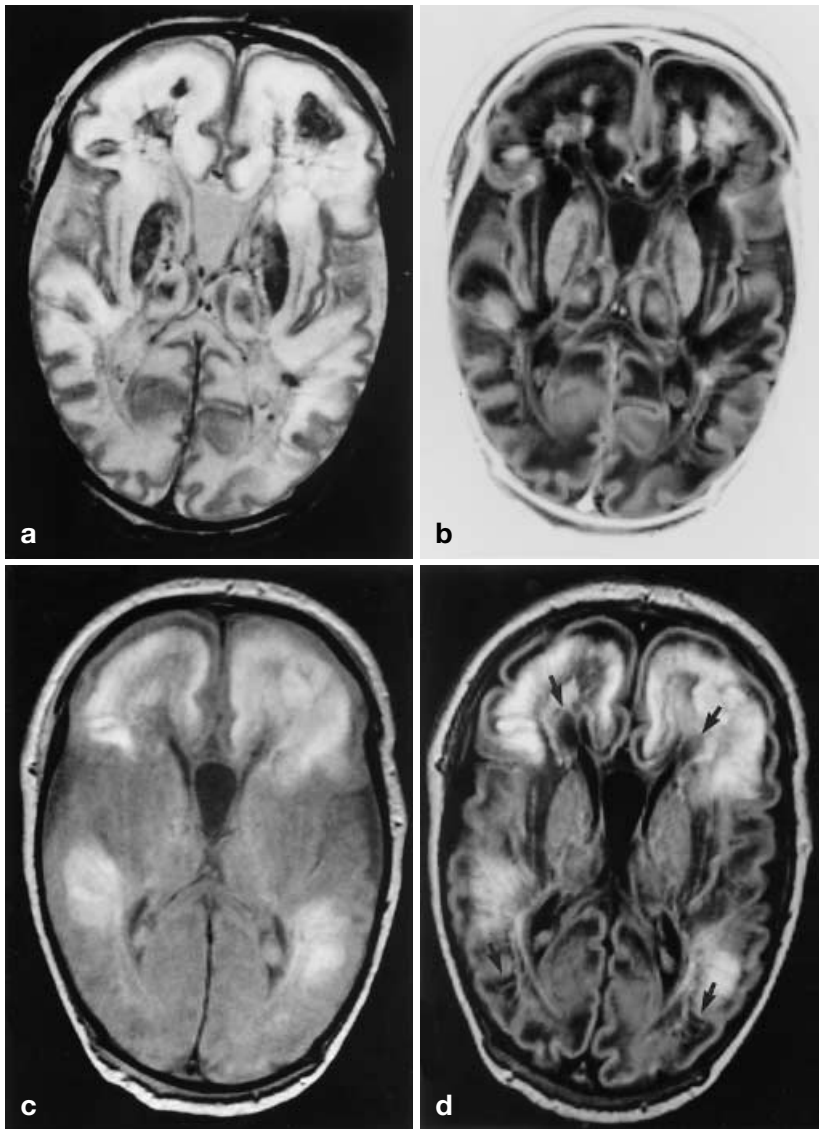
a Axial T2-weighted, b IR, c proton-density-weighted, and d FLAIR MR images in a neonate born at 37 weeks, with a postconceptional age of 39 2/7 weeks (case 9) show extensive SI changes throughout the white matter and lesions in basal ganglia and thalami. Conventional MR imaging (a, b) is superior in differentiating these lesions into ischemic changes (low SI on IR images, and high SI on T2-weighted images) and hemorrhages (high SI on IR images, and low SI on T2-weighted images). Proton-density-weighted (c) and FLAIR (d) images show a more diffuse hyperintensity without much differentiation between ischemic and hemorrhagic changes, whereas the cystic component is better seen with FLAIR sequence (*arrows* in d). Diffuse white matter damage with large cystic lesions was confirmed at autopsy performed 4 days later
